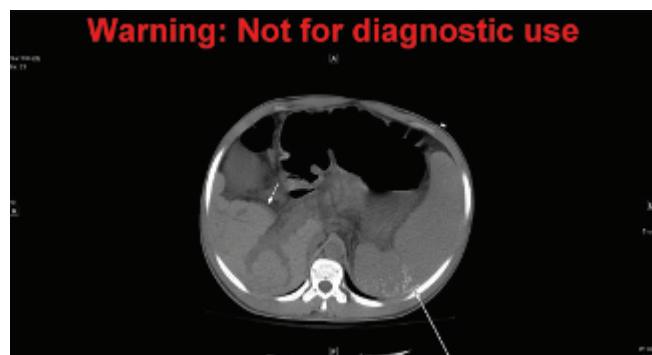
Noncontrast axial computed tomography image through upper abdomen showing small liver with nodular contour, consistent with cirrhosis (short arrow), and enlarged spleen containing both fine parenchymal and linear capsular calcifications (long arrow).
